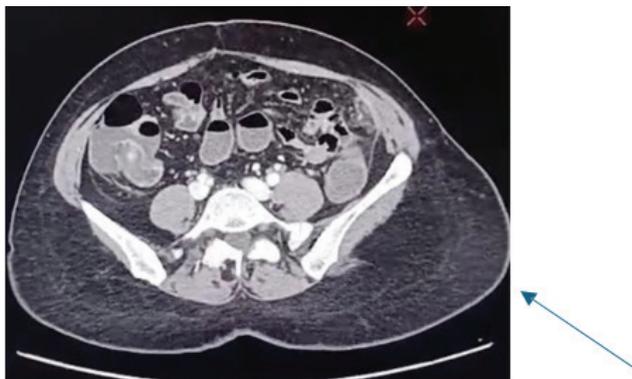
CT scan depicting focal linear hyper density in peritoneal fat in left iliac fossa overlying mid/distal jejunal loops with perifocal fat stranding.
